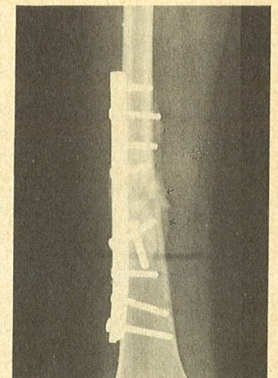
Post-operative radiograph following open reduction and internal fixation along with the application of allograft bone paste.
